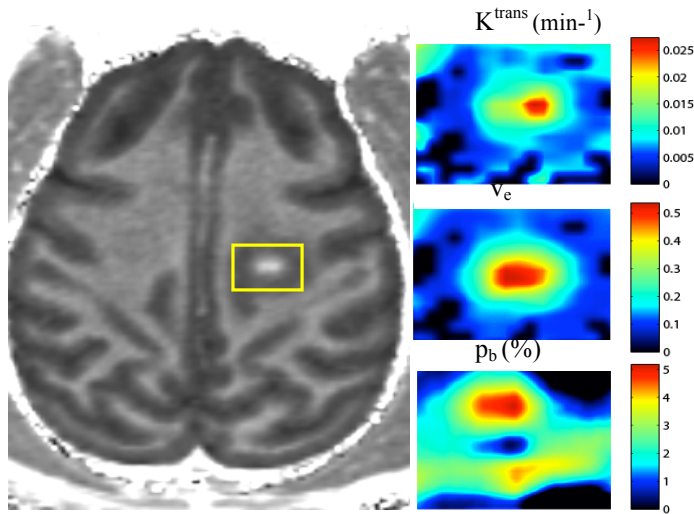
The left panel shows a T₁-w image acquired 40 minutes post gadoteridol injection in an acute JME case. The centrum semiovale white matter lesion outlined by yellow box shows marked signal enhancement consistent with a broken blood-brain barrier (BBB). The lesion properties were quantified using DCE-MRI. The top color image shows the lesion and surrounding tissue K^{trans} map with scale bar at right. The maximum K^{trans} observed for this lesion was $\sim 0.03 \text{ min}^{-1}$, consistent with human multiple sclerosis. The middle color panel shows the gadoteridol distribution volume fraction map, mostly the interstitial volume or extravascular extracellular volume fraction (v_e) with values at the lesion core that approach 0.5. The bottom color image shows the blood volume fraction (p_b) map. The p_b map was calculated during the first pass of contrast agent and was corrected for leakage. Interestingly, the lesion blood volume maximum value approach 5% which is nearly 3x that of contralateral normal appearing white matter that had a mean value of 1.7% (data not shown). The marked increase in blood volume and leaky nature of blood vessels is consistent with angiogenesis.
